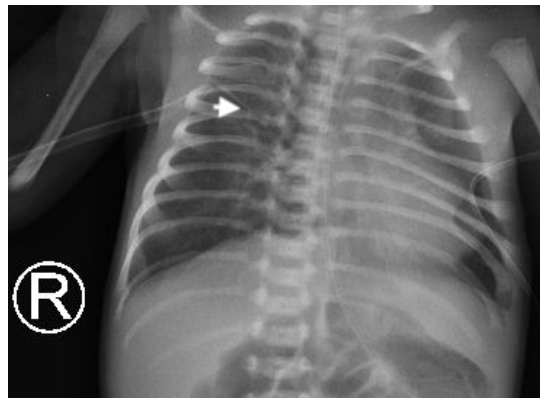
Thorax x-ray post-chest intercostal drainage
